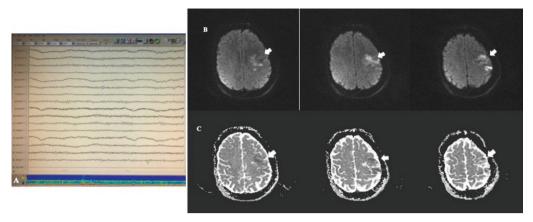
Normal electroencephalogram (A). Magnetic resonance imaging of brain-diffusion weighted axial image showed a restriction in the left frontal opercular cortex, suggesting acute and subacute infarct (B, C)
